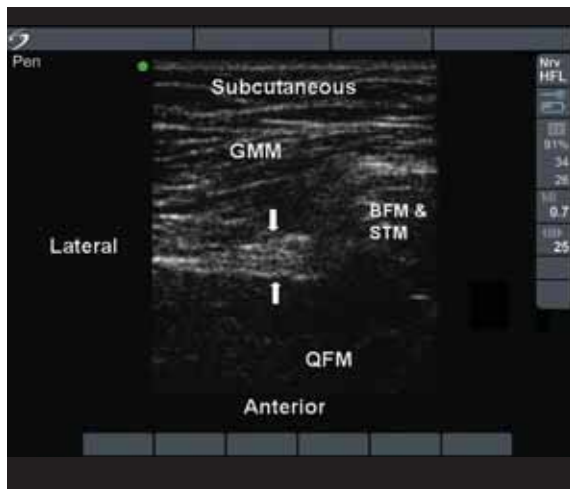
Ultrasound image for subgluteal sciatic block.
